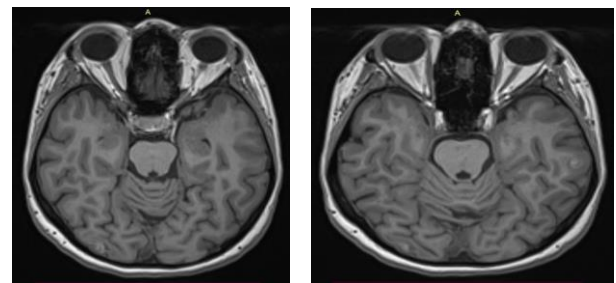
2 months after discharge MRI. Important shrink of the main foci (right occipital lesion and left parietal lesion) and complete remission of the other lesions. No edema was emphasized.
